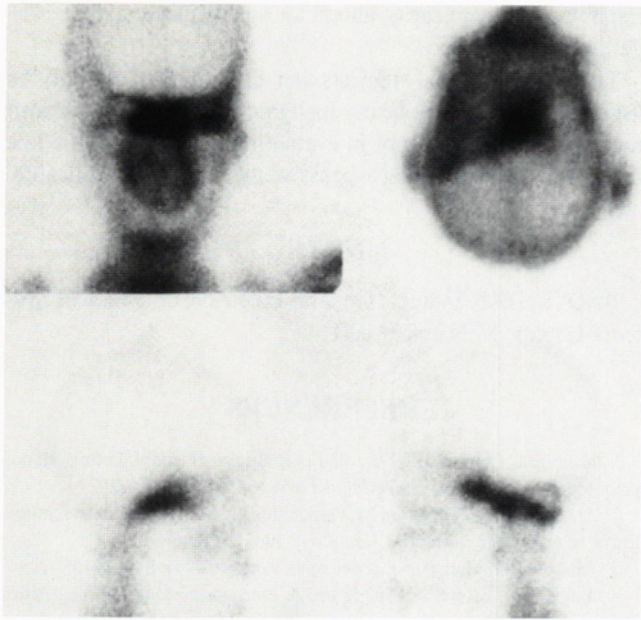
Planar bone scintigrams demonstrating increased uptake of ^{99m}Tc -MDP in skull base (anterior, vertex, right lateral, left lateral).
